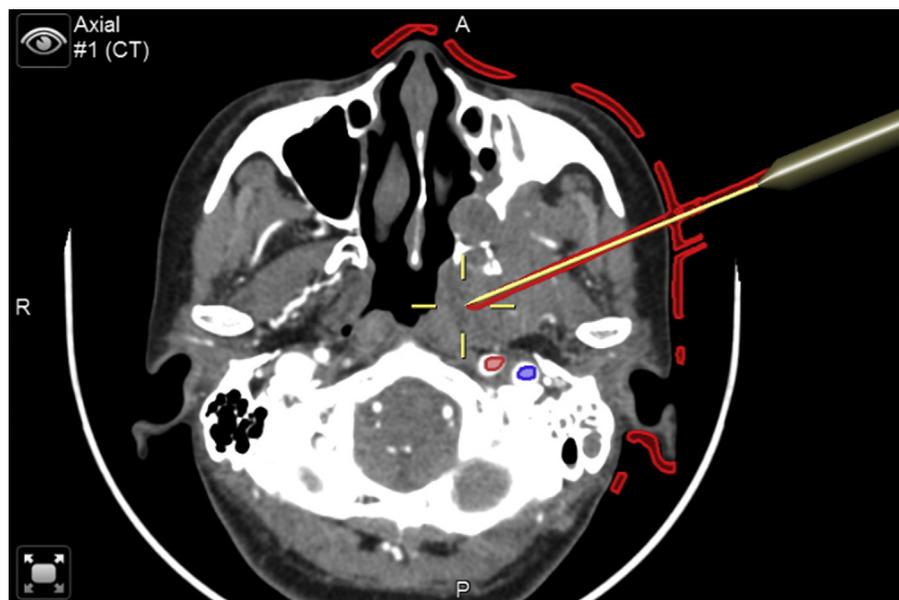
Needle tip location verified by navigation system using computed tomography.
